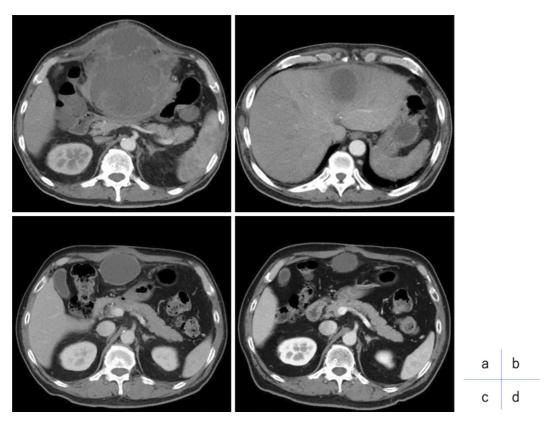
Clinical course on CT. (a, b) Abdominal contrast-enhanced CT scan on admission. A liver abscess with a maximum diameter of 14 cm was visible in the left lobe of the liver. The abscess reached not only the liver parenchyma but also the subcutaneous fat tissue below the rectus abdominis muscle. (c) Abdominal CT scan with contrast at 5 months after the onset (approximately 4.5 months after termination of MNZ administration). The abscess had been reduced. No lesion existed within the abdominal wall. (d) Abdominal CT scan with contrast at 12 months after the onset. No exacerbation of the abscess is apparent. The only finding is of the liver cyst.
